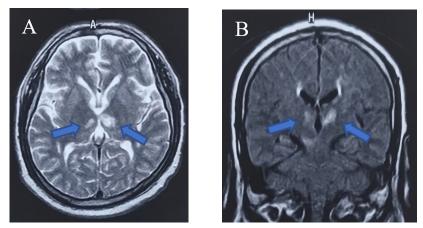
A) Axial T2 FLAIR MRI showing bilateral ischemic infarction in the thalamic region without evidence of white matter lesions, and without evidence of hemorrhage or infarct complications (blue arrows). B) DWI is observed with diffusion restriction and with lesions present in bilateral thalamic region (blue arrows), in a coronal section without presence of infarct complications, without hemorrhage or midline displacement.
